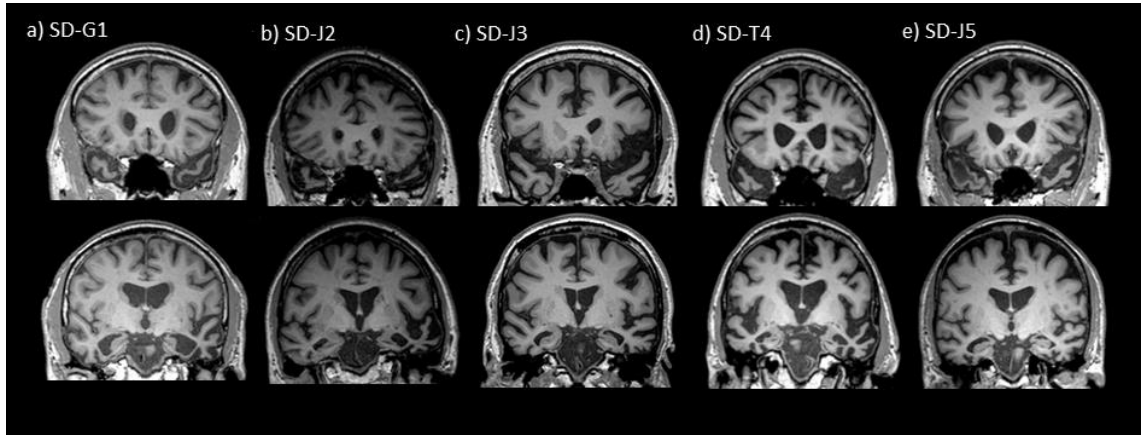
Coronal T1 weighted MRI of the anterior (top) and medial (bottom) temporal lobe for each participant.
